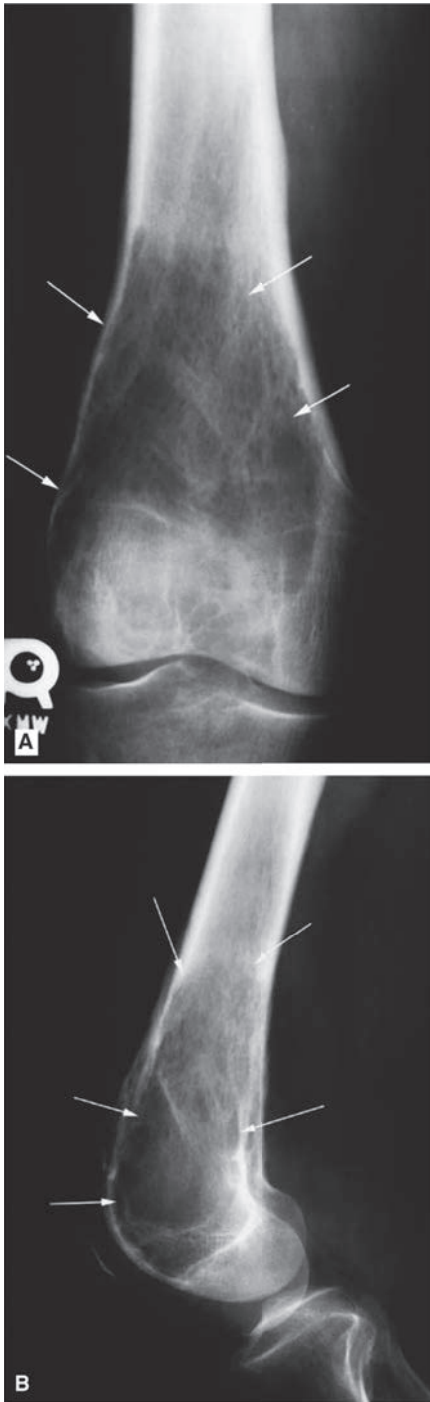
Giant cell tumor of bone involving the right distal femur. AP (A) and lateral (B) radiographs in a 37-year-old male show a lytic lesion involving the metaphysis and extending to the epiphysis (*arrows*). It has a mixed benign and aggressive appearance, with the lateral margin being well defined and the proximal margin more ill defined.
